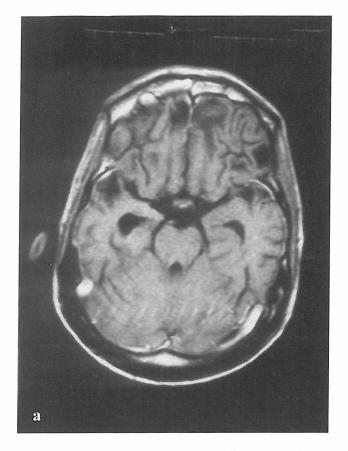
(a-b): Herpes meningo-encephalitis; Axial (a) and coronal (b) T1 weighted postcontrast MR images in an HIV seropositive patient infected by herpes shows typical temporal meningoencephalitis.
